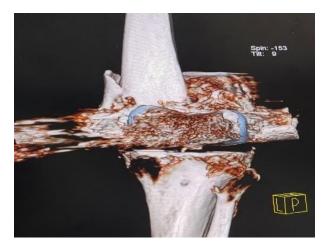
3D CT reconstruction image of type 3 femoral component fracture with supracondylar fracture and fracture of prosthetic medial condyle of femur [R].
